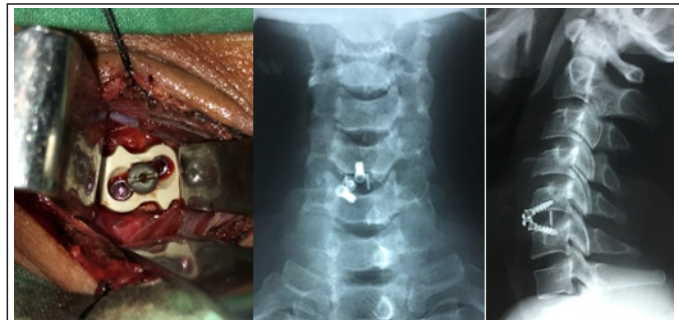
Intraoperative image and post-operative X-ray showing placement of standalone polyetheretherketone cage with a screw.
